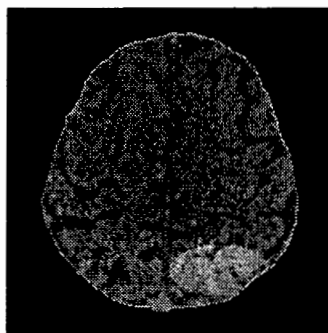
CT Image with artificially added lesion
